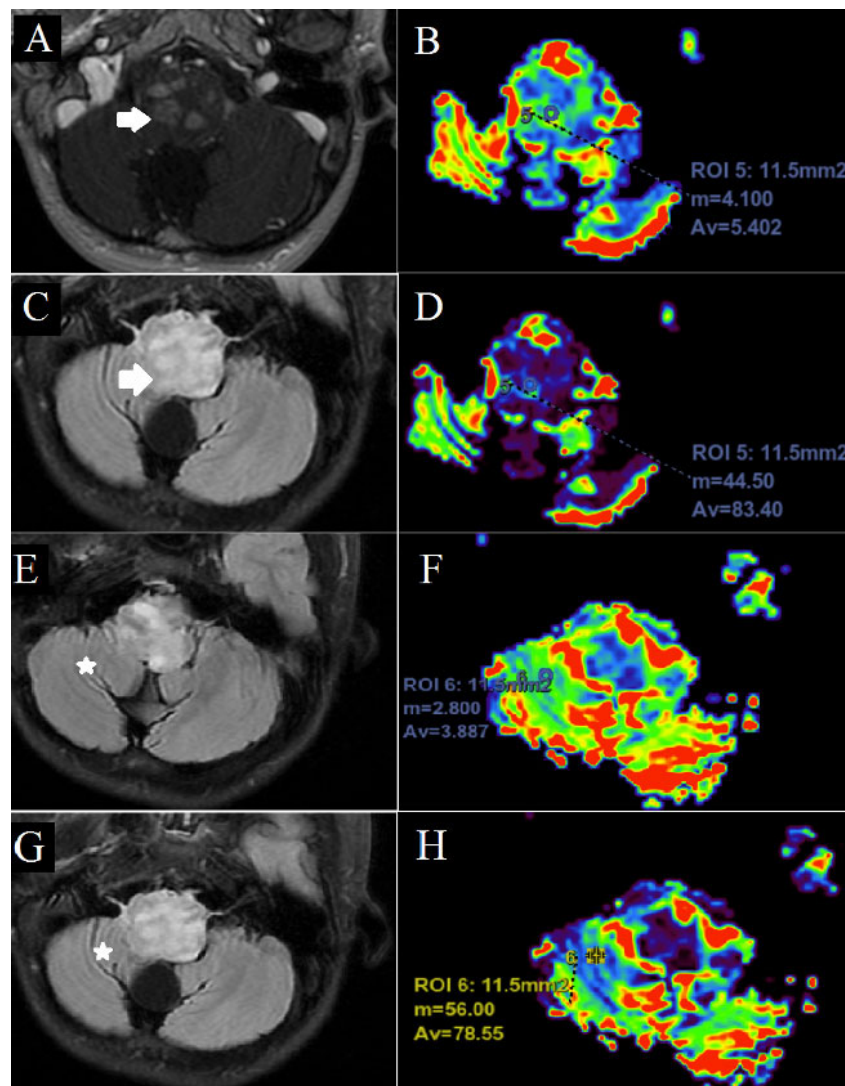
A 14-year-old male patient presented with a mild headache for 4 months. This image presents an analysis of the same patient from Figure 1 at a lower level, where the tumor manifests “hot spots” on the cerebral blood volume (CBV) color map compared with the normal white matter parenchyma of the cerebellum. Axial T1-weighted contrast-enhanced (A) and axial fluid-attenuated inversion recovery (FLAIR, B) imaging show a diffuse mass in the brainstem (white arrows). The tumoral ROI was placed to capture the greatest intensity on the CBV (B) and cerebral blood flow (CBF) maps (D). Axial FLAIR (E-G) images at the same level show the normal white matter parenchyma (stars) used for placing ROIs on the CBV (F) and CBF maps (H).
